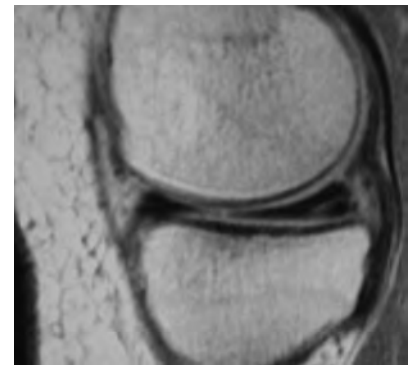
Meniscal tear seen on an MRI scan. The tear is a white line through the black triangle representing the meniscus. (ortho pics - meniscal tears)
